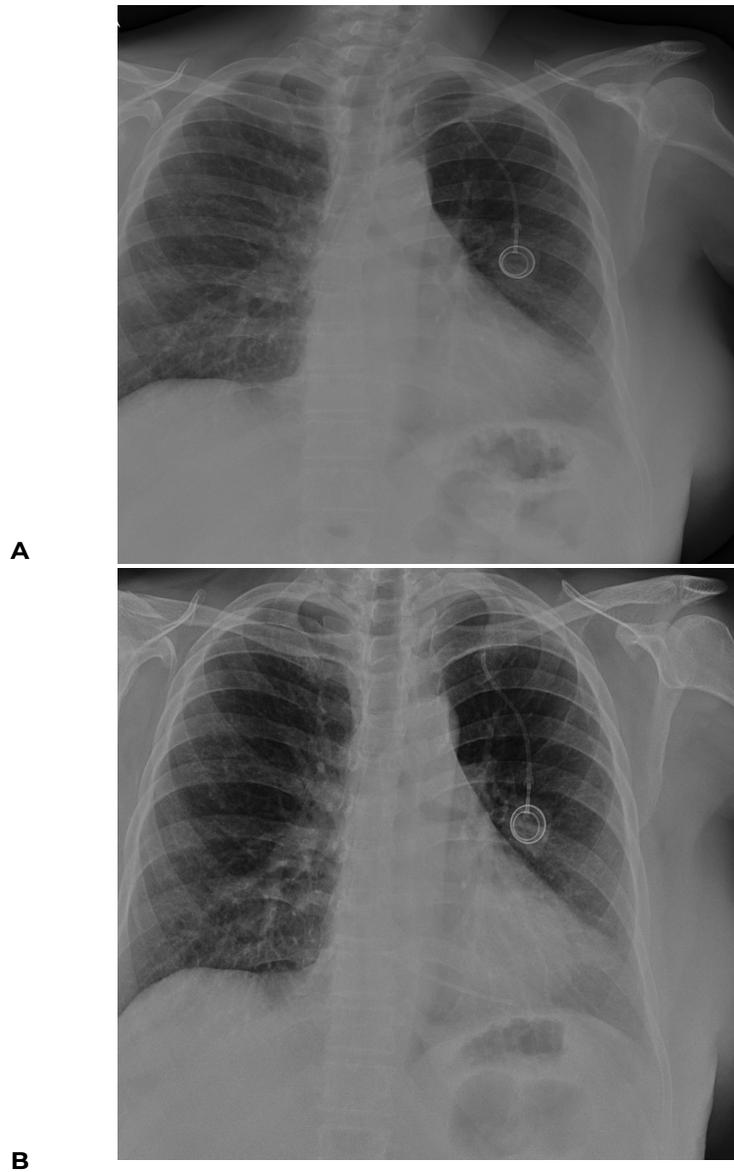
Standard chest X-ray comparison. A) Reservoir catheter in the normal position along the internal jugular vein trajectory; B) The proximal end of the reservoir catheter is located in the right atrium and ventricle.
